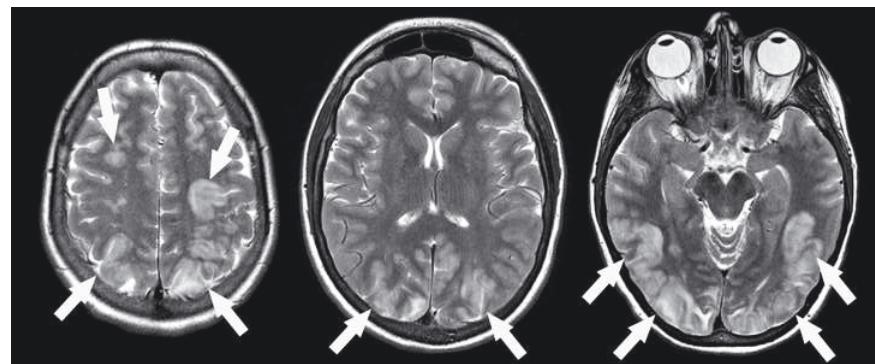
Cortical, multifocal involvement. Axial T2-weighted imaging in a patient with hypertension-induced RPLS.
